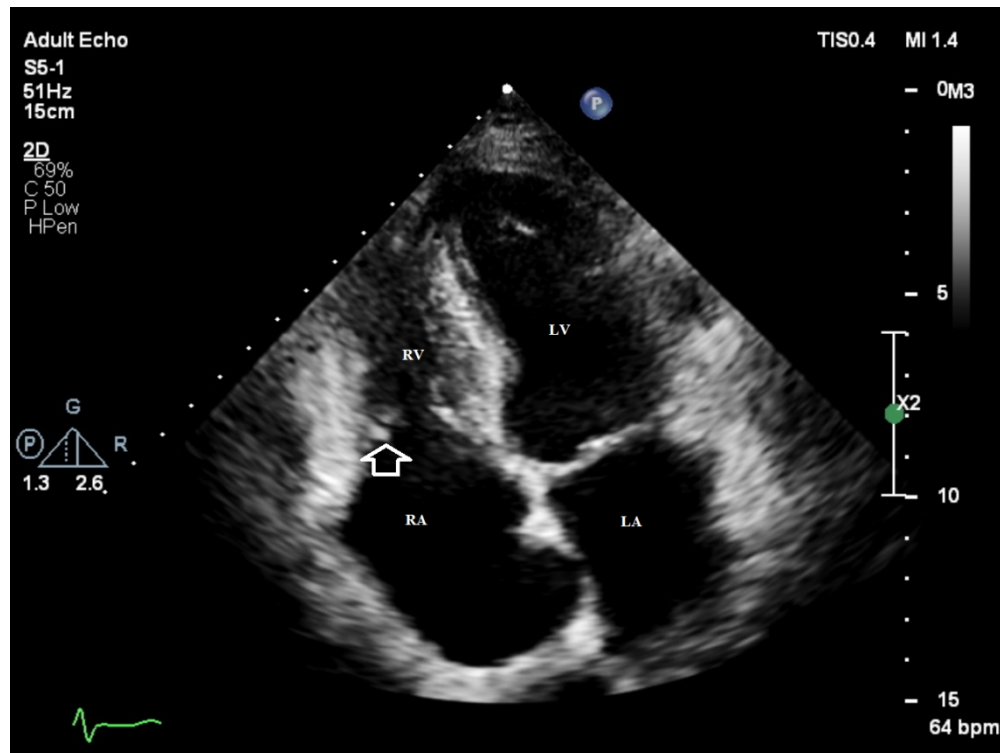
Apical four-chamber view from a transthoracic echocardiogram demonstrating the hallmark features of thickening, restriction of motion and retraction of the tricuspid valve leaflets, indicated by the arrow. The image has been frozen at end-systole, before the atrio-ventricular valve leaflets should be open but, in this case, the tricuspid valve leaflets are clearly open at a time when the mitral valve leaflets are closed. LV=left ventricle; LA=left atrium; RV=right ventricle; RA=right atrium.
